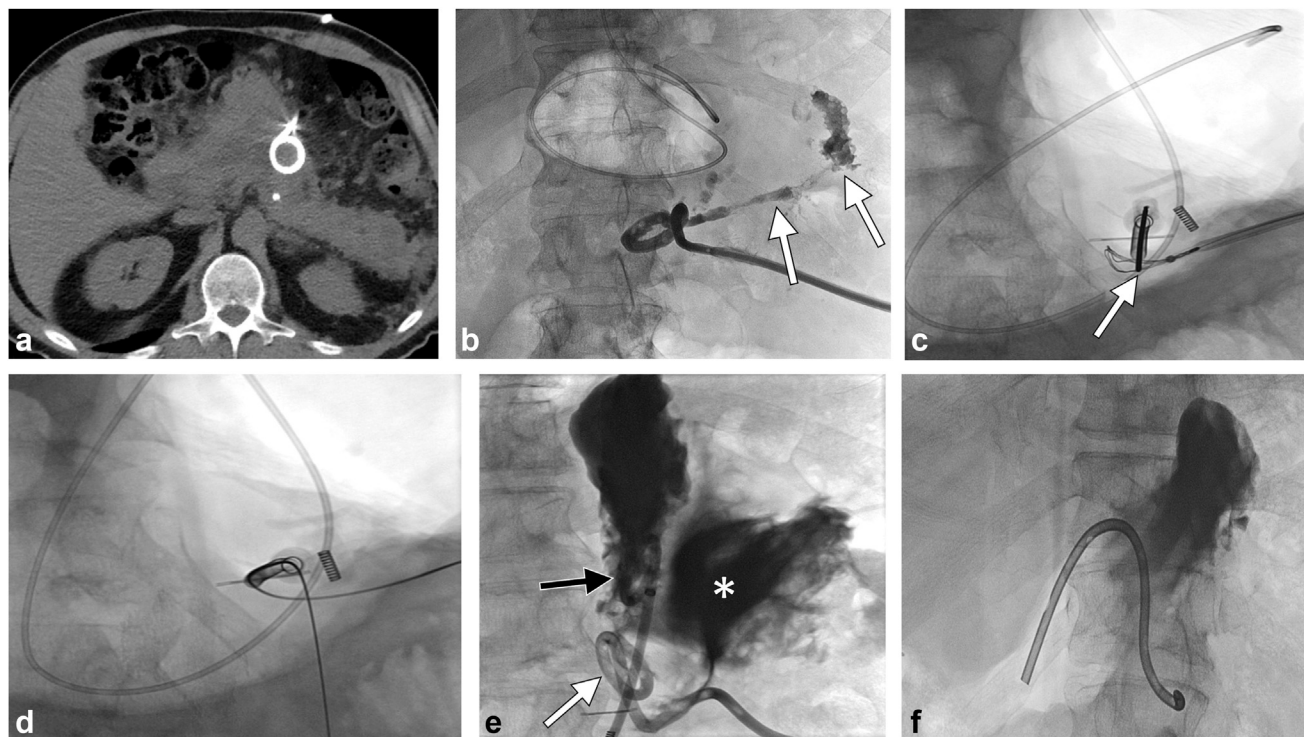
Conversion from direct percutaneous drain to transgastric drain. (a) A preprocedural computed tomography scan demonstrated a direct percutaneous drain terminating in the peripancreatic region with phlegmonous changes. This patient had persistent high output from the drain suggestive of pancreaticocutaneous fistula. (b) Initial contrast injection of the direct percutaneous drain outlined the peripancreatic collection (arrows). (c) The direct percutaneous drain was exchanged for a gooseneck snare. After single point gastropexy, a sheath was placed. A needle was introduced through the sheath, targeting the snare (arrow). (d) A wire was introduced through the gastrostomy sheath needle and snared, providing through-and-through access. (e) A locking loop drainage catheter was placed with pigtail terminating in the stomach (white arrow) and side holes communicating with the peripancreatic collection (asterisk). An additional pigtail catheter was placed in the stomach (black arrow) for future access using the gastrostomy access. (f) The patient subsequently had their drain completely internalized at a follow-up appointment. This was later retrieved transorally once the collection resolved on computed tomography.
